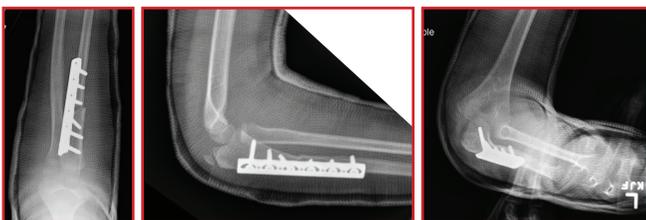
Immediate post operative x-rays after ulnar osteotomy and now concentric reduction of the radial head
